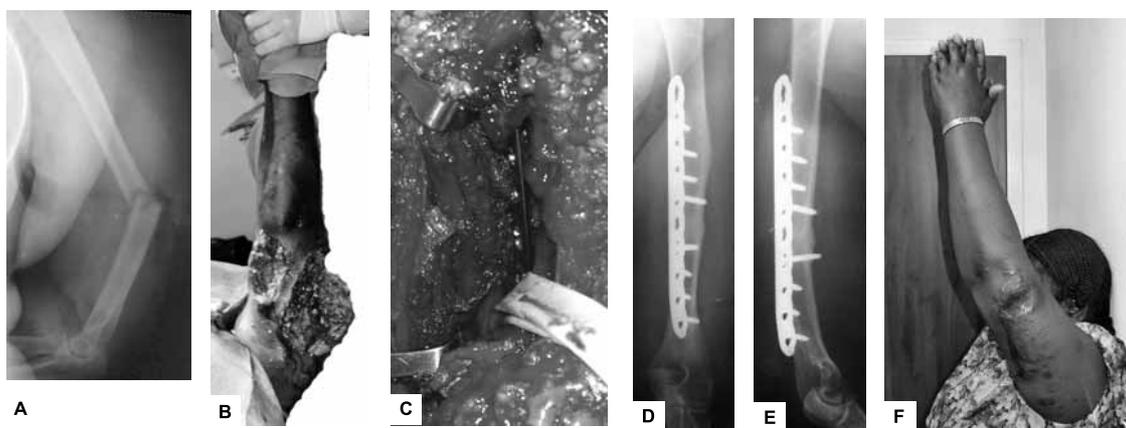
A. X-ray of transverse humeral shaft fracture with some free fragments and foreign bodies. B. Clinical photo three hours after turn-over vehicle accident with posterolateral and anteromedial soft tissue defects. C. Clinical photo of locked compression plate covered well by soft tissues and put in immediately after irrigation and debridement, redraping and redraping of the extremity. D. AP x-ray view of the healed fracture 16 months after injury. E. Oblique x-ray view with healed fracture and two classical screws used to achieve axial compression, and locked unicortical screws to enhance fixation. F. Early motion facilitated by stable fixation, healing without infection resulted in excellent function after couple of months, here on 16 month follow-up.
